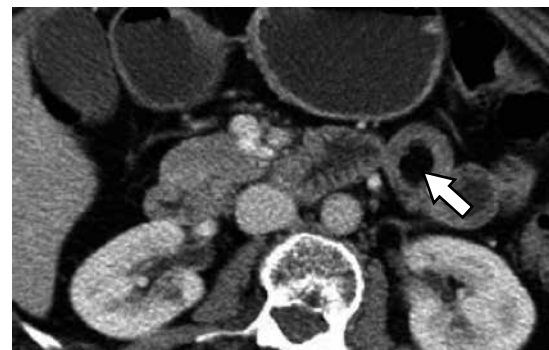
CT. Axial cut: Image with fat density, located in the wall of the jejunum that corresponds to lipoma (arrow).
